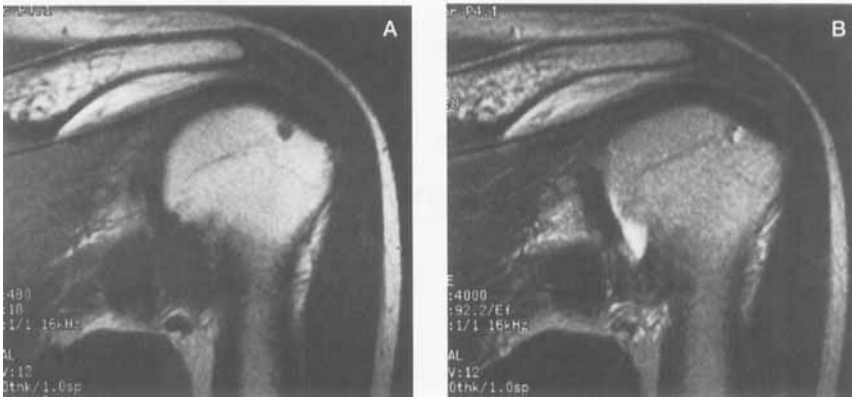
A cystic change in a normal shoulder. T1-weighted image (A) shows a low signal-intensity lesion in the posterior half of the middle facet. The lesion showed high signal-intensity on the T2-weighted image (B).
